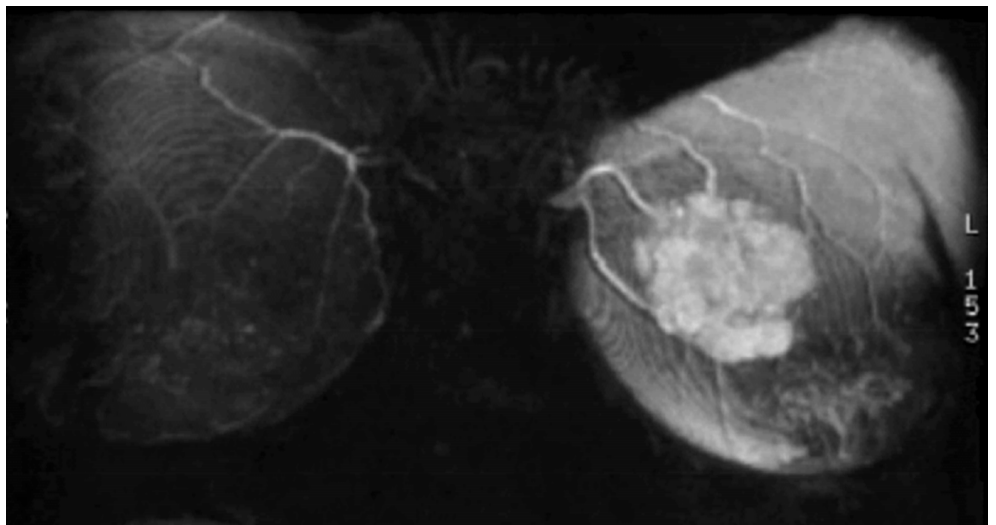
MRI (coronal MIP reconstruction): in the left breast note the presence of a gross nodular enhancement area with regional hypervascularization.
